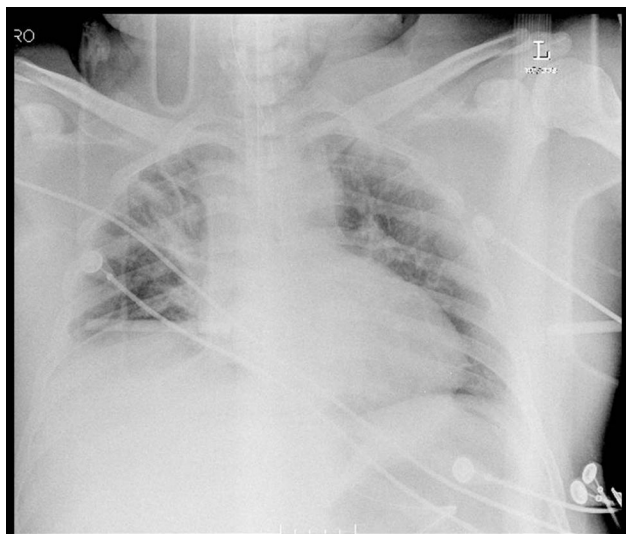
Radiograph on admission day 3 is consistent with ARDS.
